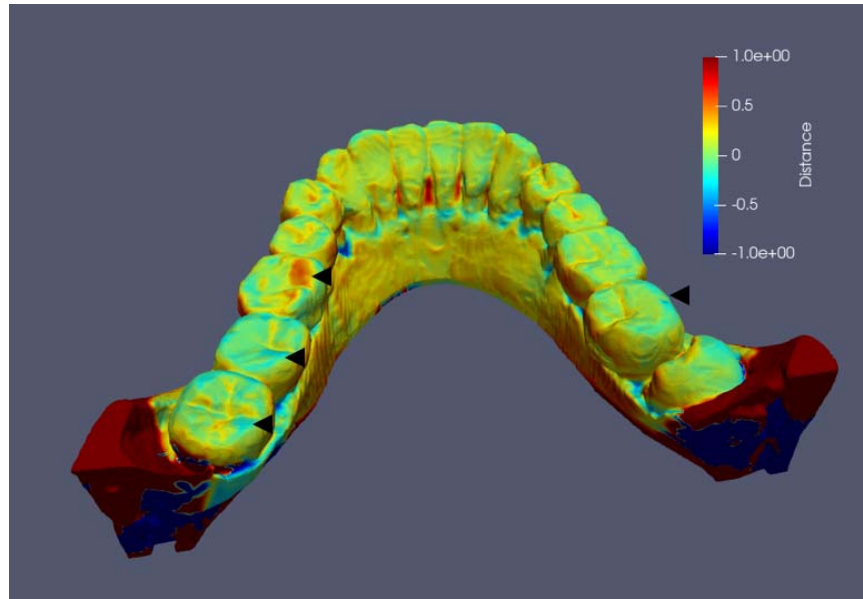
Color map superimposition between IOS and CBCT DMs. Notice the deviation from 0.5–1.0 mm (arrowhead) mainly at the molar area.
